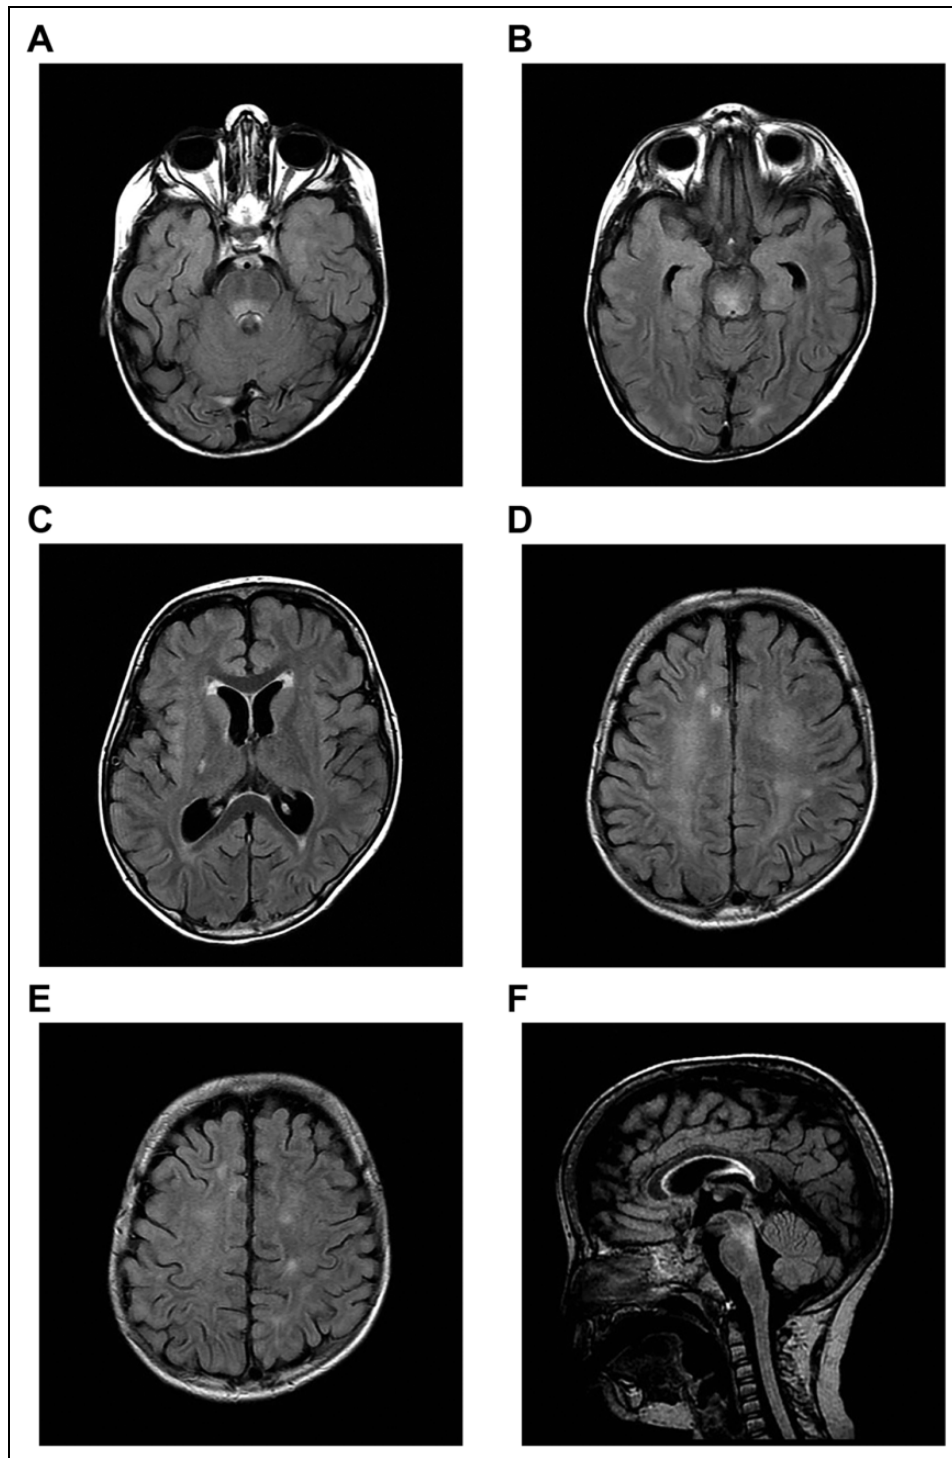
MRI Brain showing interval regression of the white matter hyper intensities on FLAIR sequences with unchanged brainstem hyper intense signal. No new lesions are seen.
